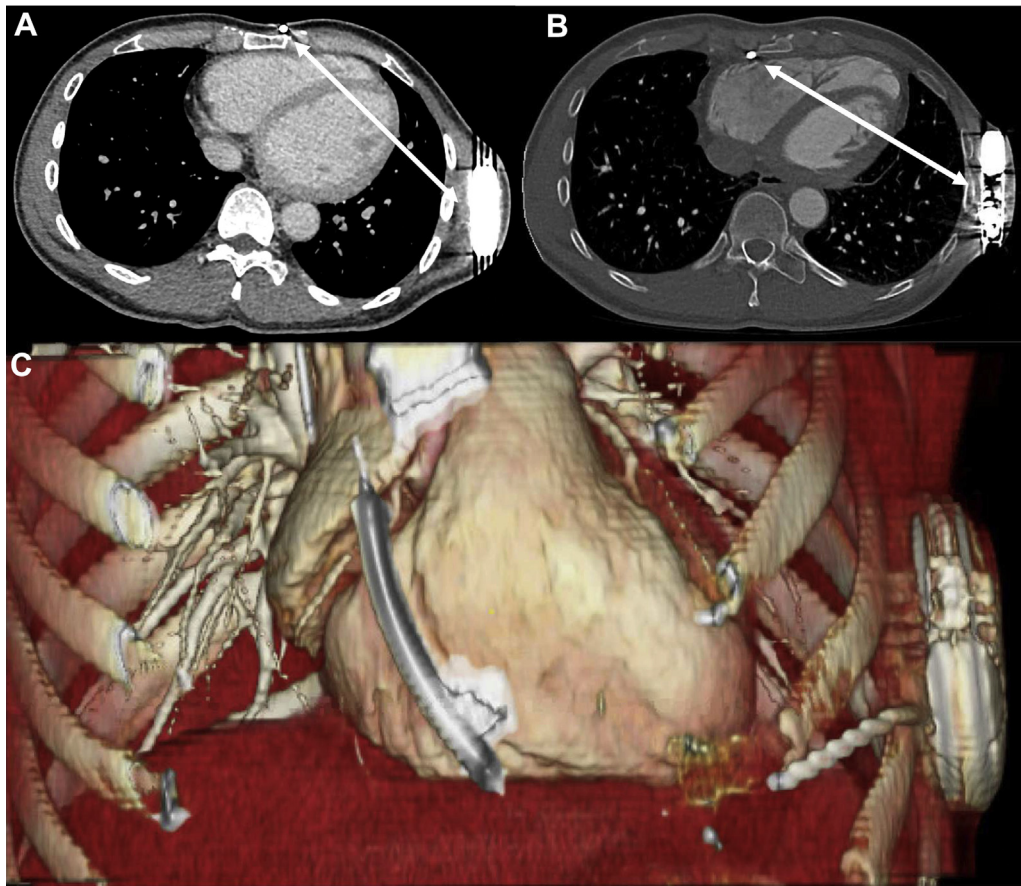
A: Chest computed tomography (CT) short-axis revealing the sparse amount of ventricular myocardium covered by the left subcutaneous lead within the sensing vector. B: Chest CT short-axis revealing improved coverage of ventricular myocardium by the right substernal lead. C: Three-dimensional reconstruction of the right substernal lead and generator position relative to the ventricles.
